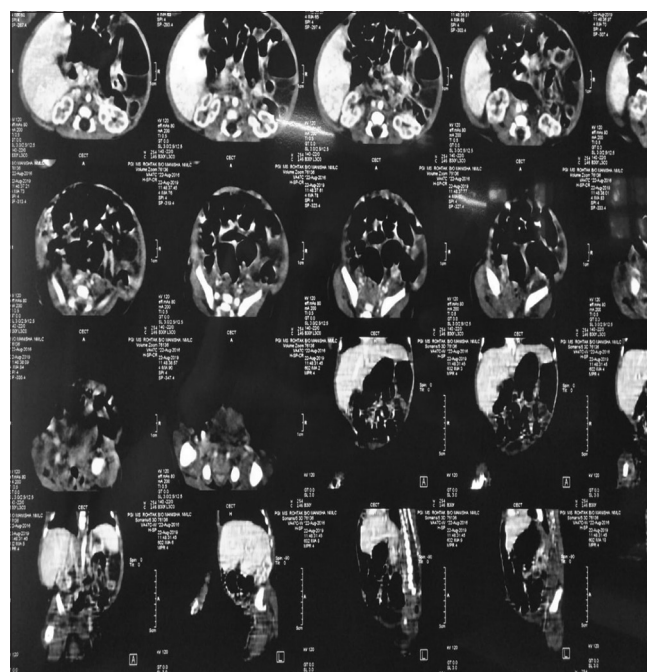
CT of the abdomen
